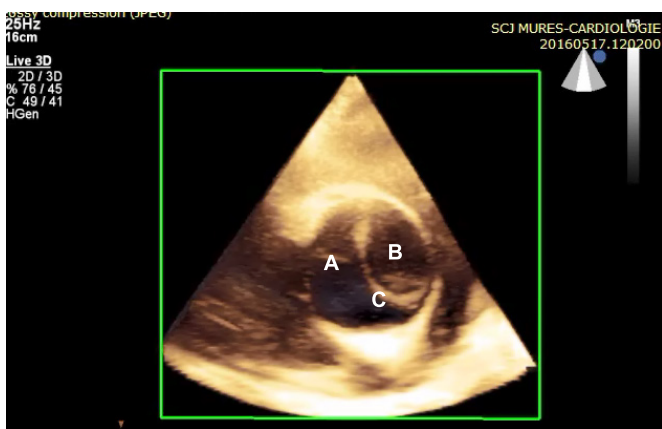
3D transthoracic echocardiography (live 3D) – parasternal short axis view (angulated superiorly): visualisation of the false (A) and true (B) lumen and the dissection membrane (C)
